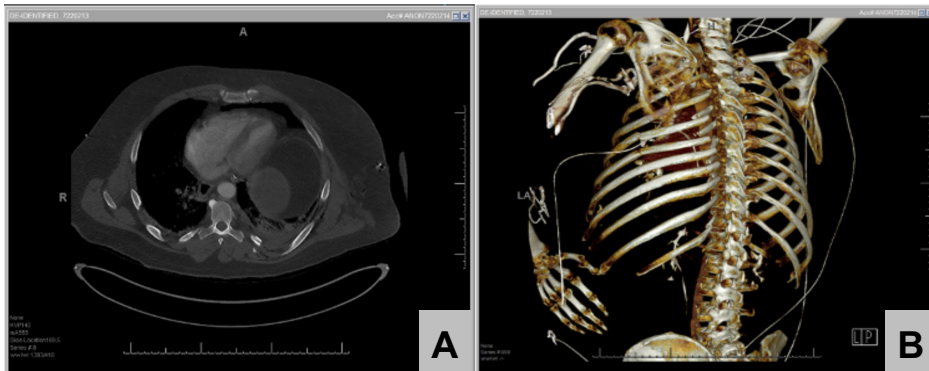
RibFracture_7 Chest CT with Standard Modality - (A) axial view; (B) bony reconstruction
